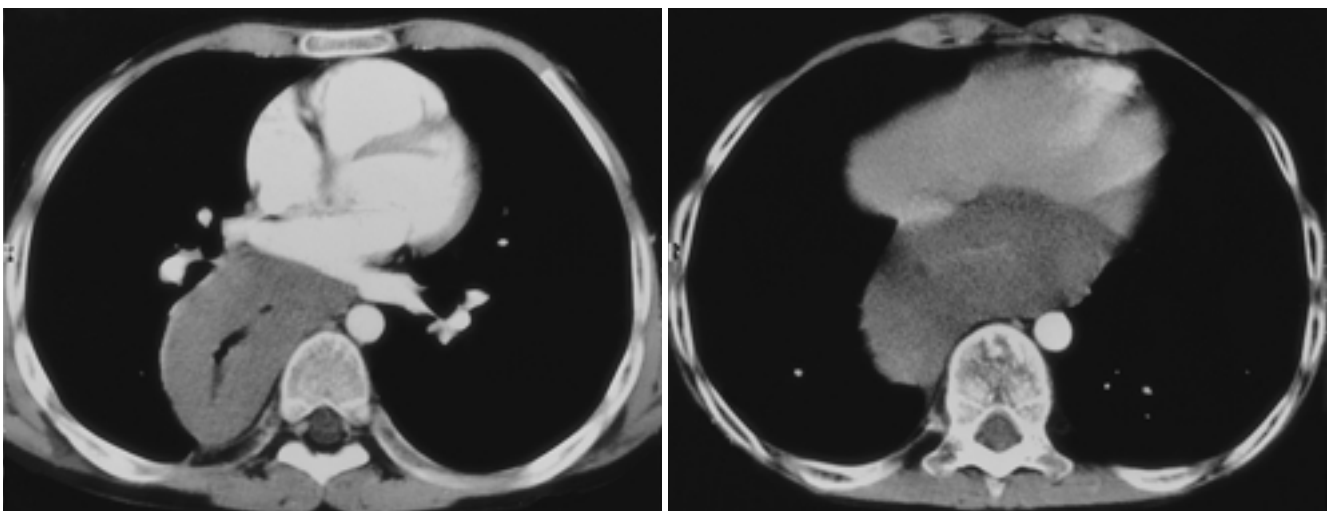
CT scan of esophagus at the level of left atrium (A) and liver dome (B) demonstrates marked esophageal dilatation with diffuse wall thickening. The density of thickened wall is homogeneous and lower than back muscles, and no contrast enhancement.
